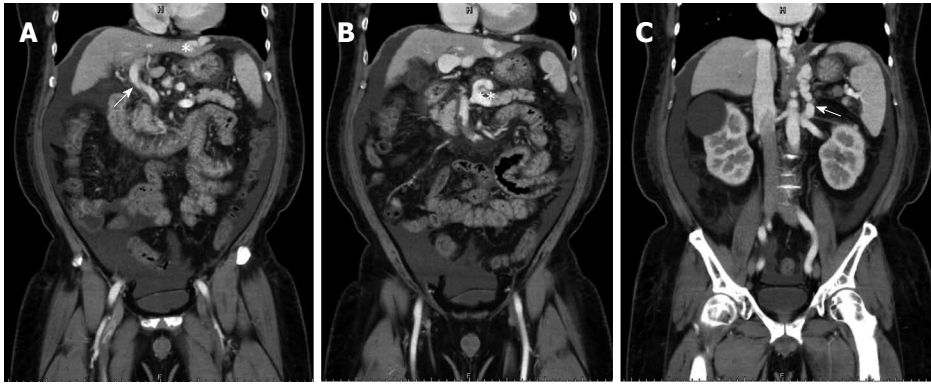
Preoperative computed tomographic findings of case 2. A: The right lobe portal vein could not be identified, likely owing to hepatofugal flow-induced stasis and thrombosis (white arrowhead) and portal-systemic shunting from the left portal vein to the left pericardiac-phrenic vein (white asterisk); B: Coronary vein engorgement (double white asterisks); C: Spontaneous splenorenal shunting was also noted (white arrow).
